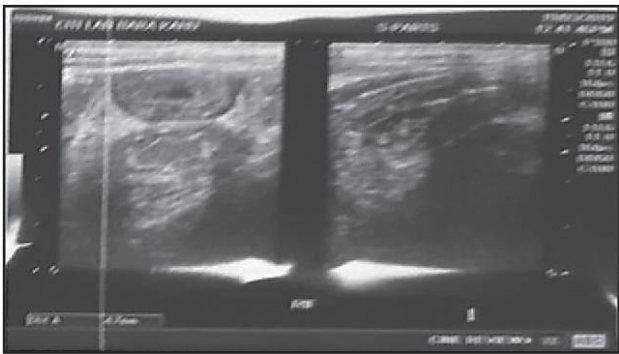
Ultrasonography film of abdomen
